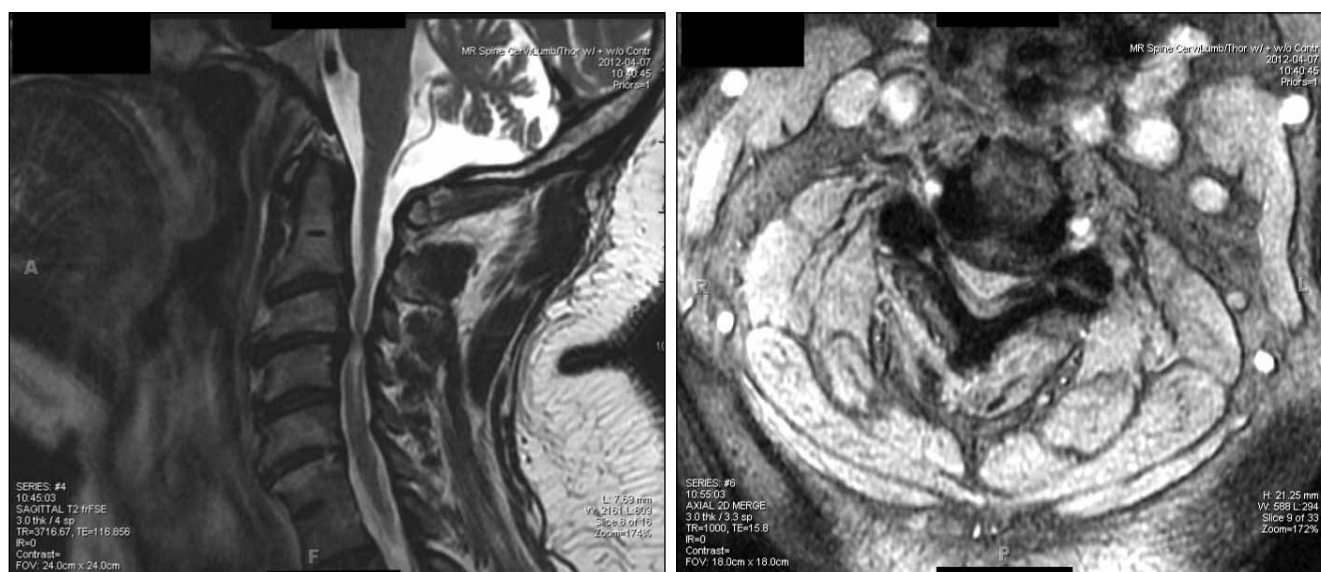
Cervical Spine MRI with and without contrast demonstrating severe cord compression most significant at the C3-C4 spinal level. Left, T2 sagittal imaging demonstrating the presence of canal stenosis and cord signal change consistent with a diagnosis of cervical myelopathy. Right, axial imaging of the cervical spine demonstrating bilateral foraminal stenosis at the C3-C4 spinal level.
